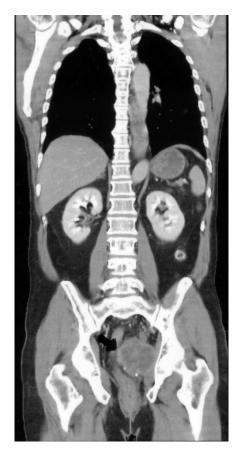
Sagittal computed tomography imaging showing an 8x5.5 cm mass in the left seminal vesicle (arrow).
